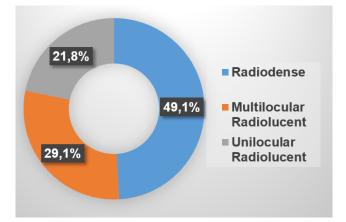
Distribution of the population according to tumors' radiographic characteristics
